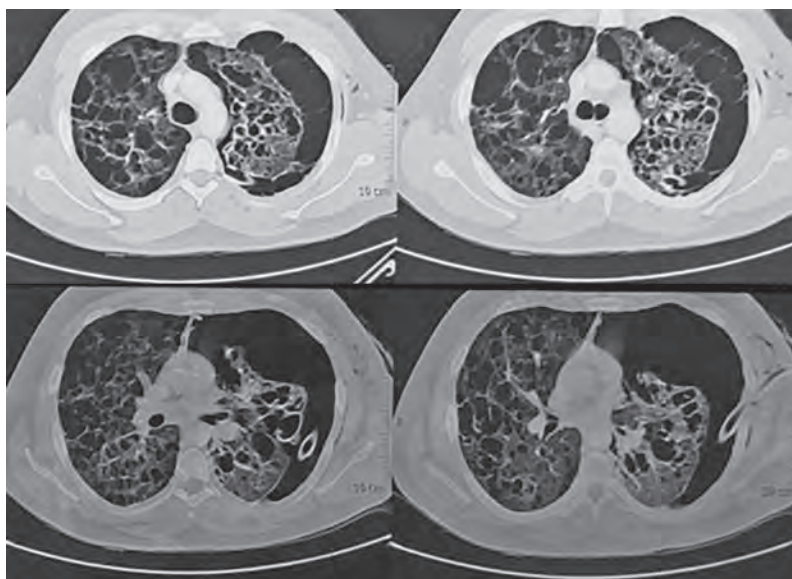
CT scan of thorax: multiple bizarre-shaped cysts in bilateral lung fields with paraseptal emphysematous changes, pneumothorax on left, and ICD tube *in situ*
